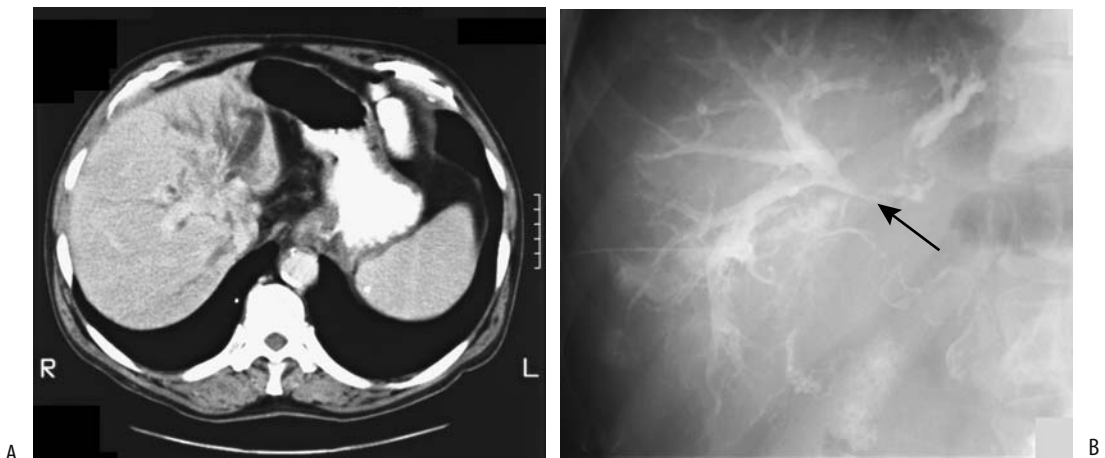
Hilar cholangiocarcinoma (Klatskin tumor). A: CT reveals dilated intrahepatic bile ducts. B: A percutaneous cholangiogram confirms obstruction at the porta hepatis (arrow). (Courtesy of Thomas Miller, M.D., San Luis Obispo, California.)
